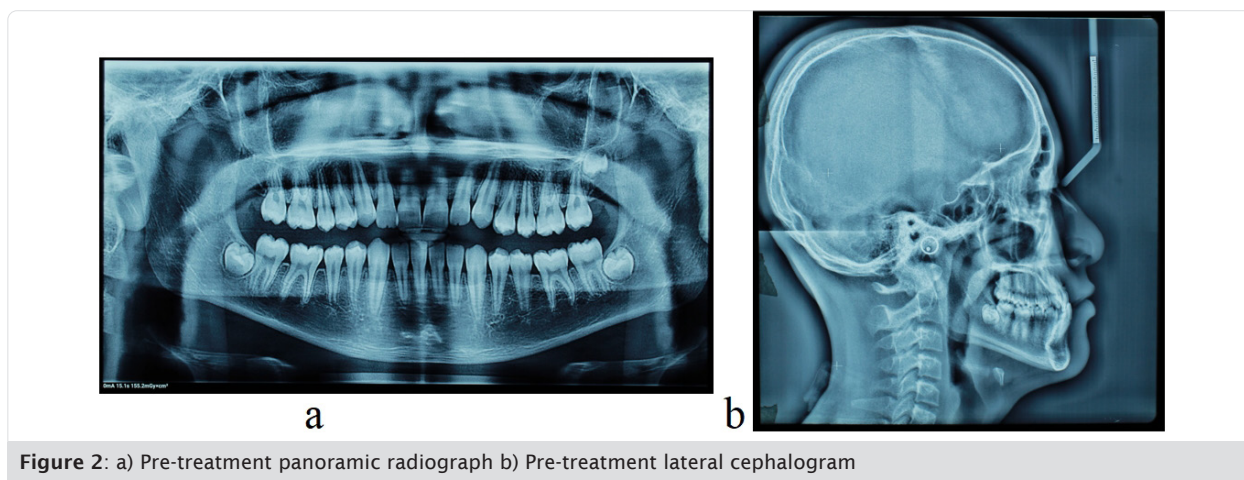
a) Pre-treatment panoramic radiograph b) Pre-treatment lateral cephalogram
